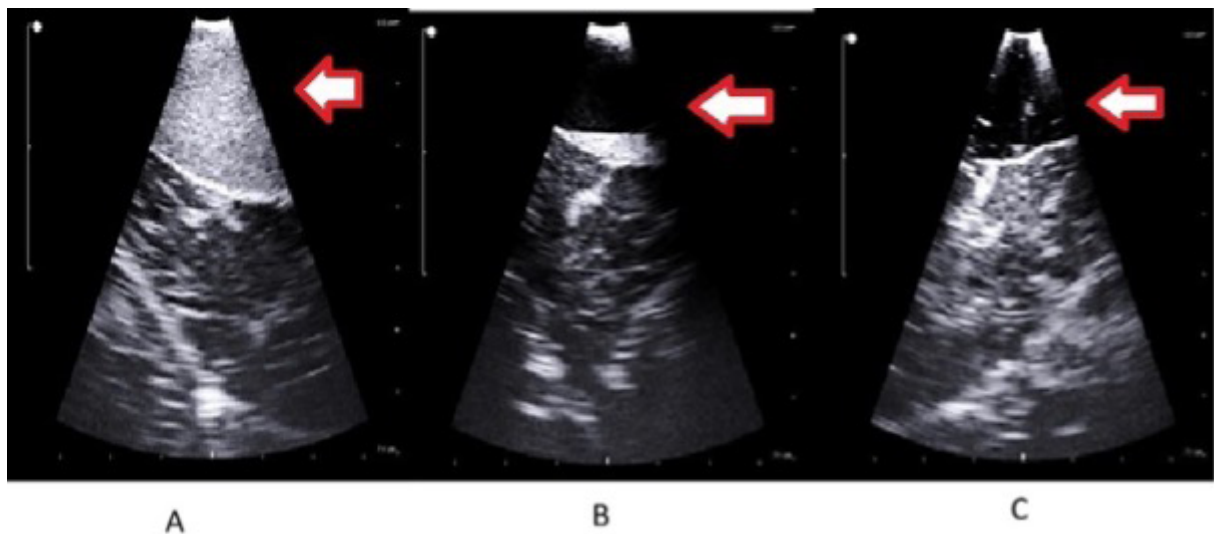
Another example of intraoperative ultrasound in another patient: A) Pre-drainage demonstrating a single homogeneous layer of hematoma; B) Post-drainage demonstrating residual deep hematoma; C) Further irrigation managed to clear hematoma, signifying complete clearance, no residual membranes seen; Arrows are pointing towards hematoma.
